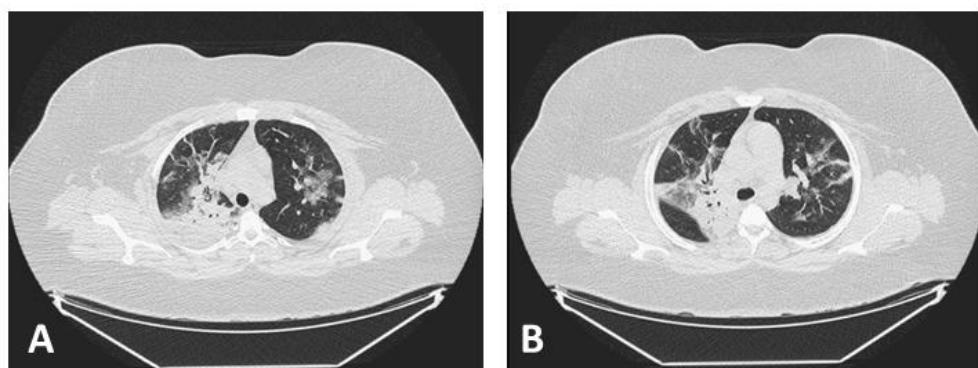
(A,B) Computed tomography scan of the chest of an 18-year-old female patient with SARS-CoV-2 infection on the day of admission, which revealed 50% ground-glass pattern.
